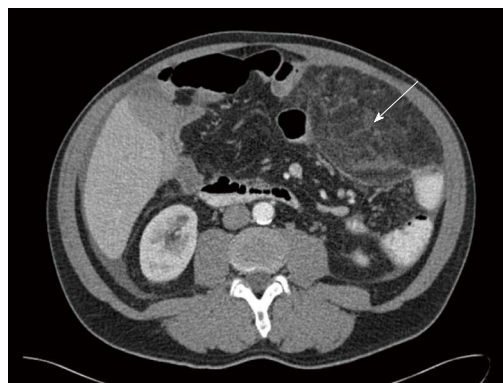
Transverse abdominal computed tomography scan with a tumor mass (15 cm × 8.8 cm × 7.8 cm, white arrow) in the upper left hemiabdomen. The mass shows increased density in comparison to normal fat and a tumoral pseudocapsule.
